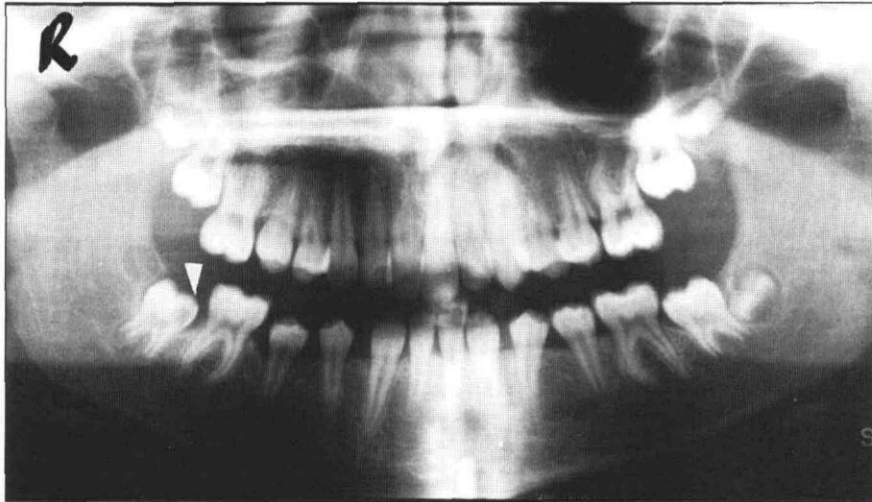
Case #2. Panoramic radiograph of 11-year-old female showing radiolucent defect in the mesial part of the crown of the unerupted and partially developed right permanent second molar. A small notch (arrowed) on the mesial occlusal, just mesial to the mesial cusp tip may be discerned on the crown of the permanent second molar, and may represent the portal of entry of resorptive tissue. However, a similar notch is also evident on the contralateral tooth, which is normal. The patient also had two congenitally missing permanent mandibular incisors.
